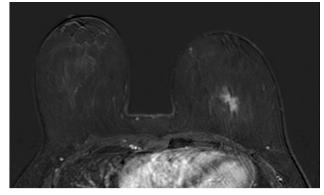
Same patient as in fig. 1. Axial contrast-enhanced T1-weighted MR image showing homogeneous enhancement of the centrally located lesion in the posterior left breast.
